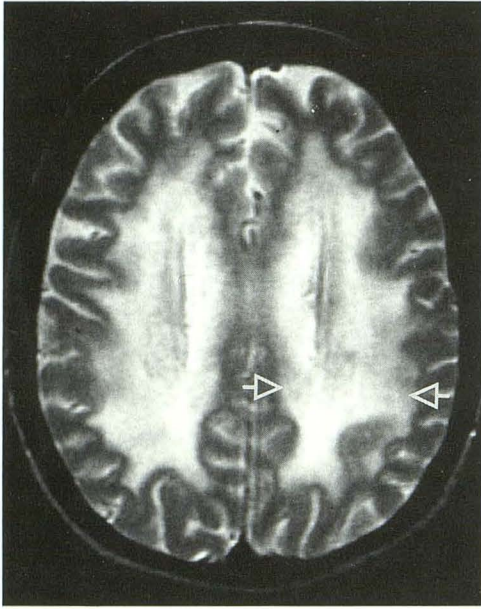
Patient 2, severe white matter change. Axial T2-weighted acquisitions (2000/80 [repetition time/echo time]) at the level of the roof of the lateral ventricles 11 months after bone marrow support. Note the diffuse, symmetric hyperintensity involving periventricular, central, and subcortical white matter (*open arrows*). This degree of severity was seen in four of the nine patients.
